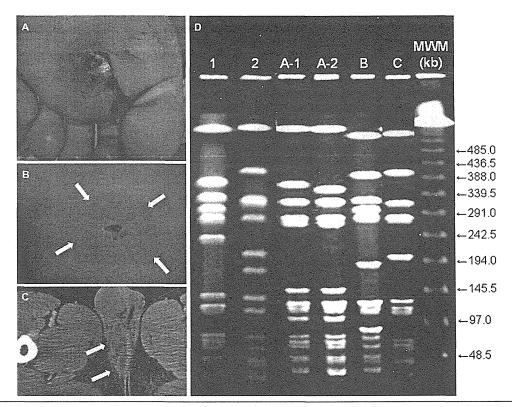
Representative lesional findings of SSTIs caused by MRSA strains (A-C) and PFGE patterns of Smal-digested DNA from MRSA isolates in the school (D). (A) Cellulitis on the left sole in case I, who belongs to a kendo club and sometimes suffers from skin abrasions on the soles of his feet. (B) Abscess (arrow) on the right buttock in case 6. Similar lesions were also observed in cases 2 and 15. (C) Computed tomography image of perineal abscess (arrow) in case 21, who experienced itching in the pubic region, which later became swollen, red, and painful. Incision and drainage was performed, and a large volume of abscess fluid was released. (D) Lane I, USA300-0114. Lane 2, USA500. Lane A-I, predominant PVL-positive SCCmec IVc MRSA strains isolated from SSTI cases and carriage examinations. Lane A-2, isolated from one student on primary examination with similar banding patterns to lane A-1. Lane B, PVL-negative SCCmec V strains isolated from 2 students on primary examination, absent on secondary examination. Lane C, PVL-negative SCCmec IV strains isolated from I student on primary examination and 3 students on secondary examination. MWM, molecular weight marker.
